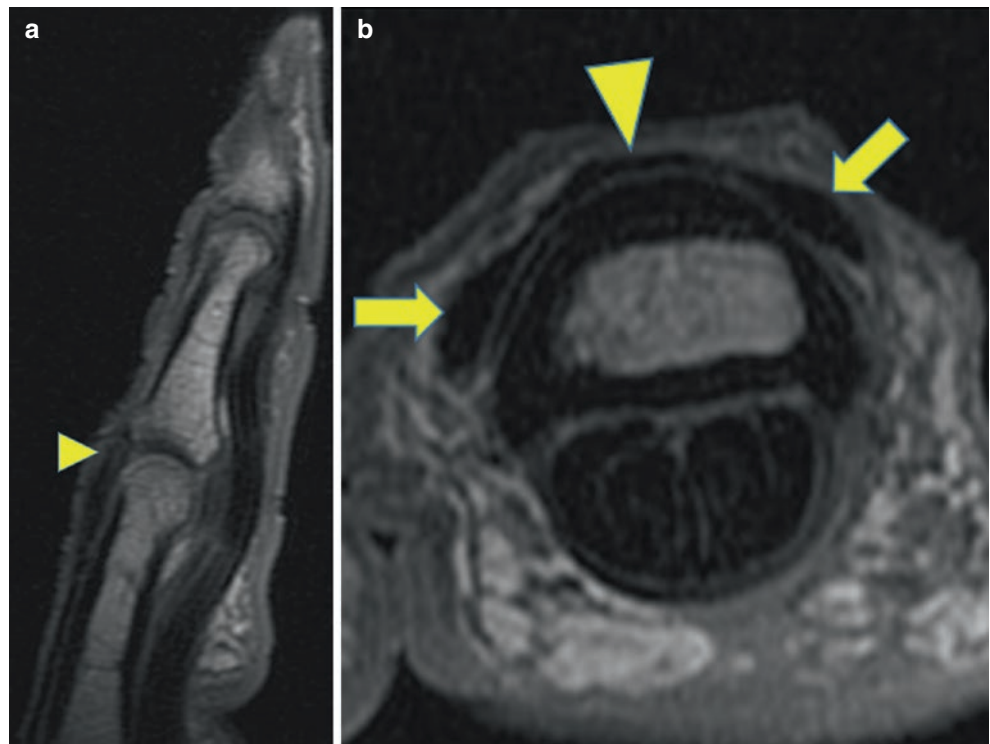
Sagittal (a) and axial (b) T1-weighted MR images profile the central slip (arrowhead) attachment of the extensor tendon to the base of the middle phalanx, with its two lateral slips (arrows)
